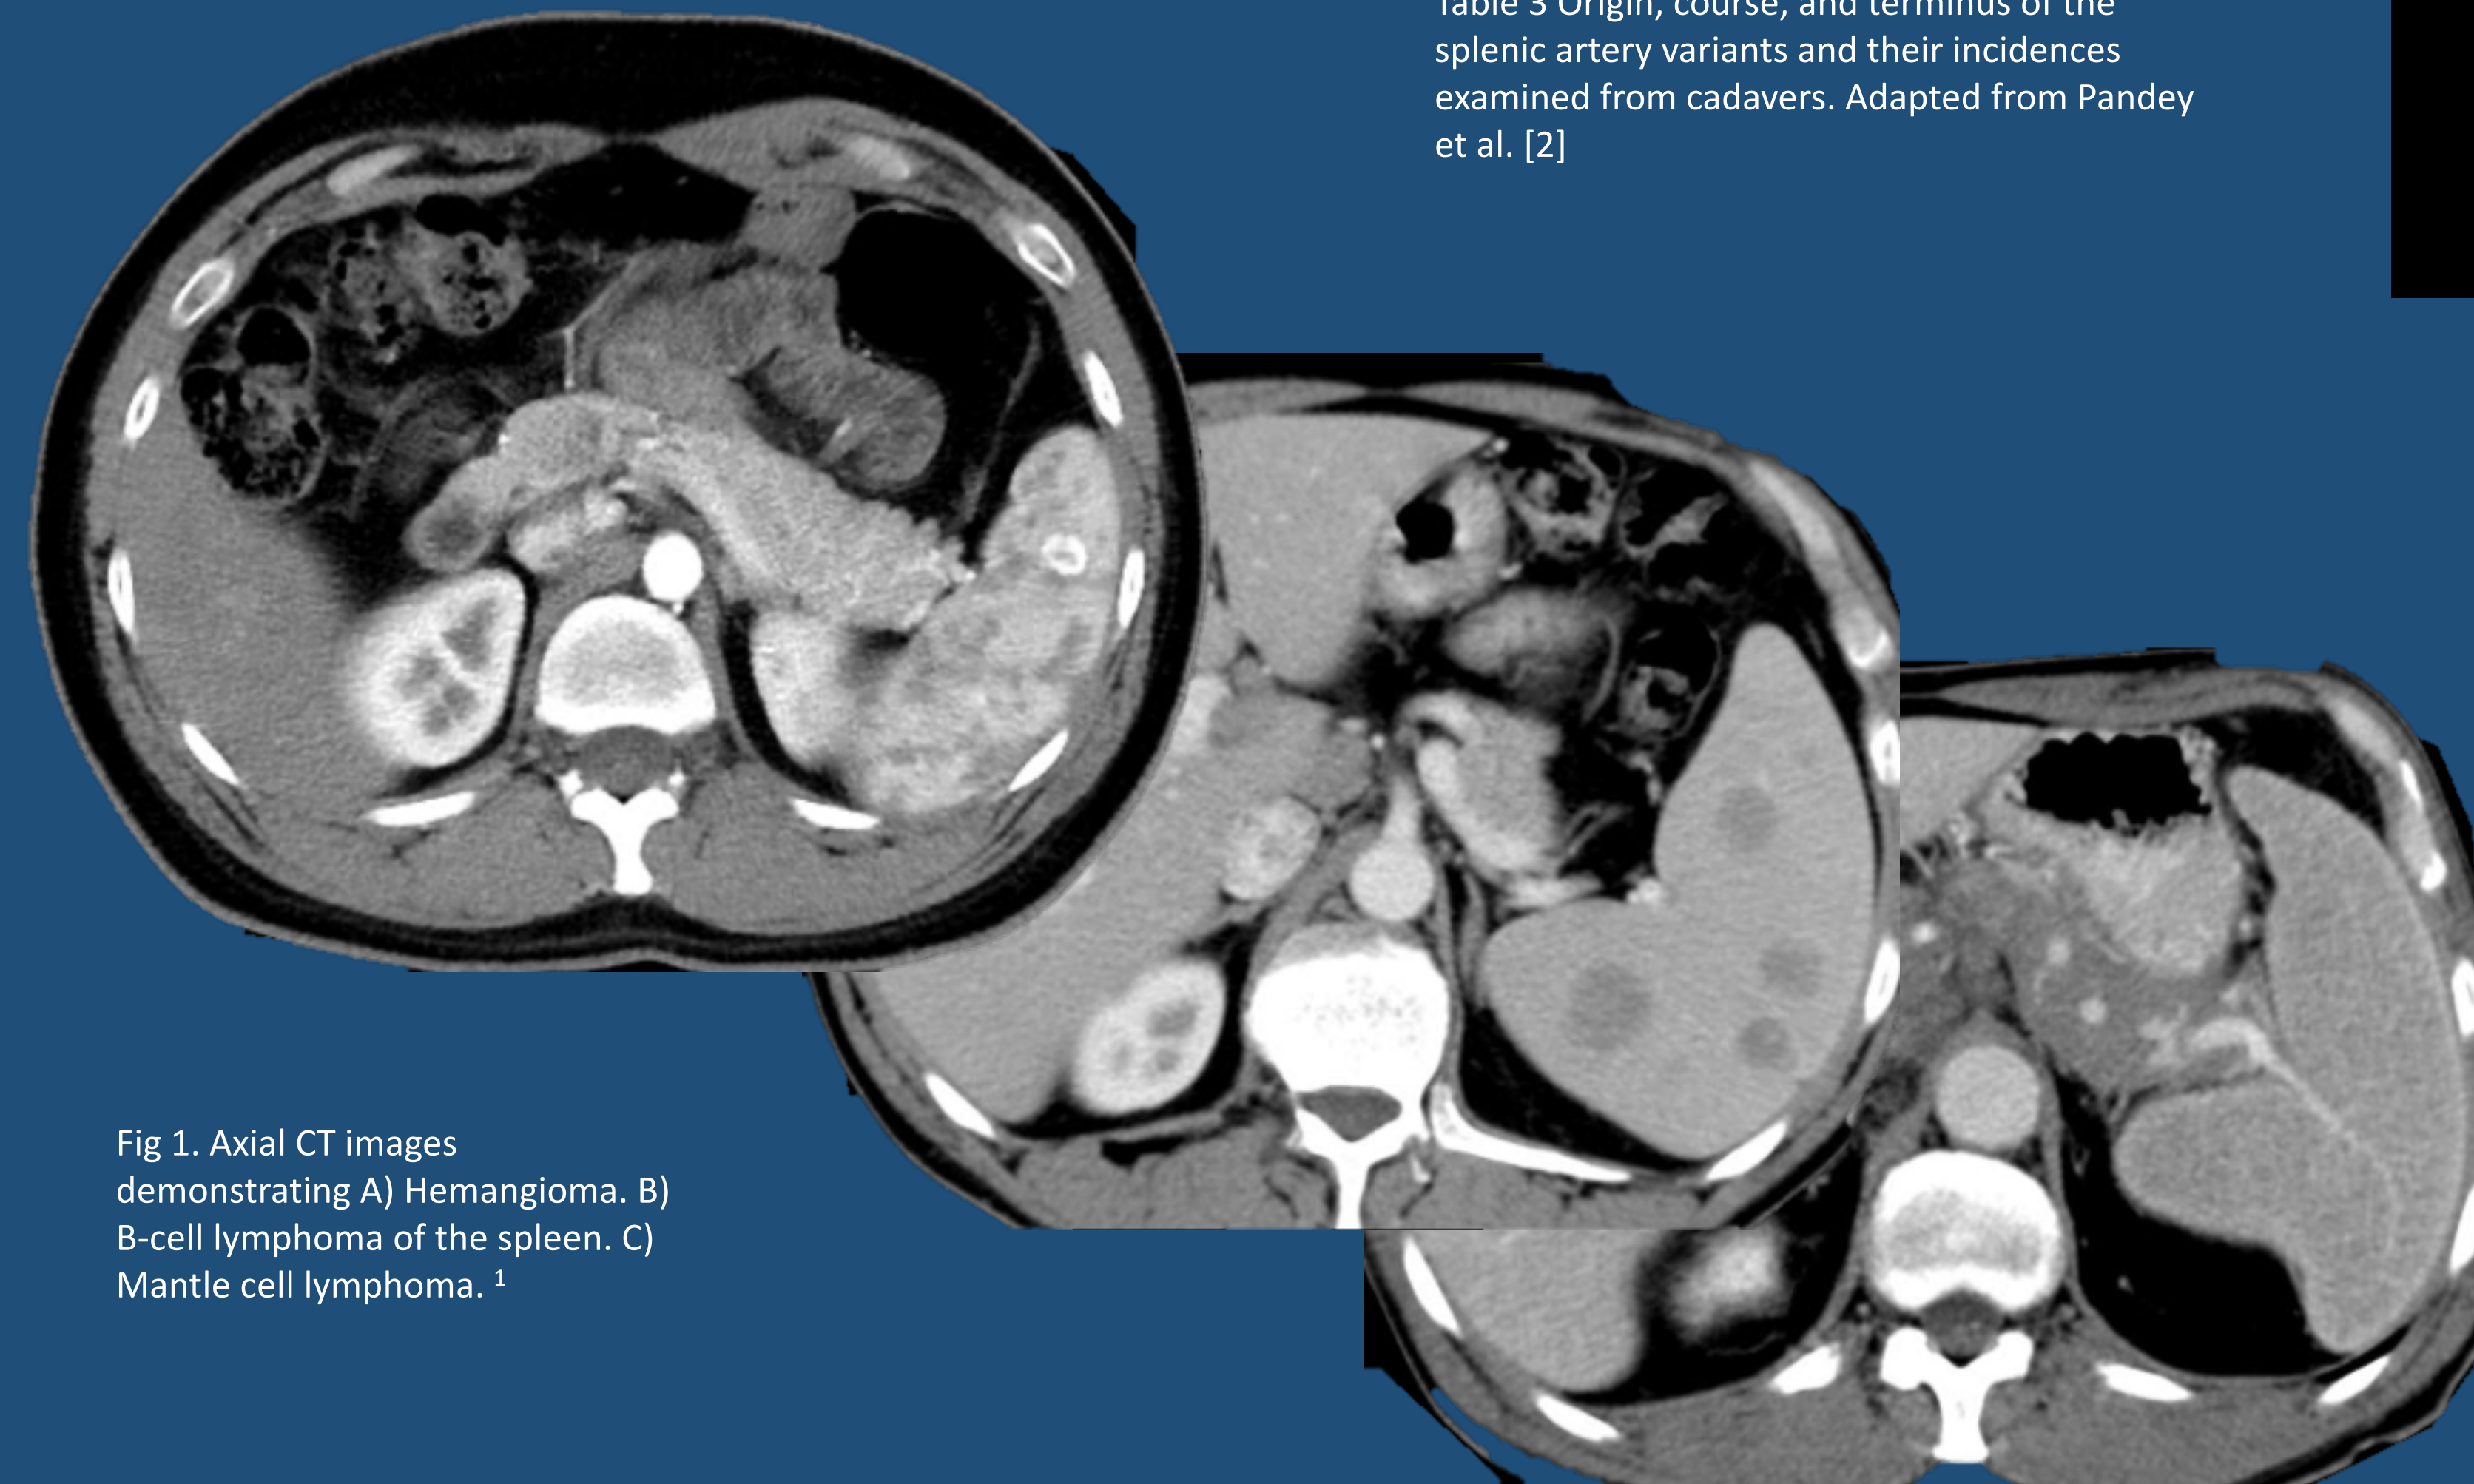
Axial CT images demonstrating A) Hemangioma. B) B-cell lymphoma of the spleen. C) Mantle cell lymphoma. ¹
